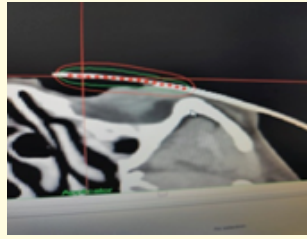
CT Scan with surface mold
